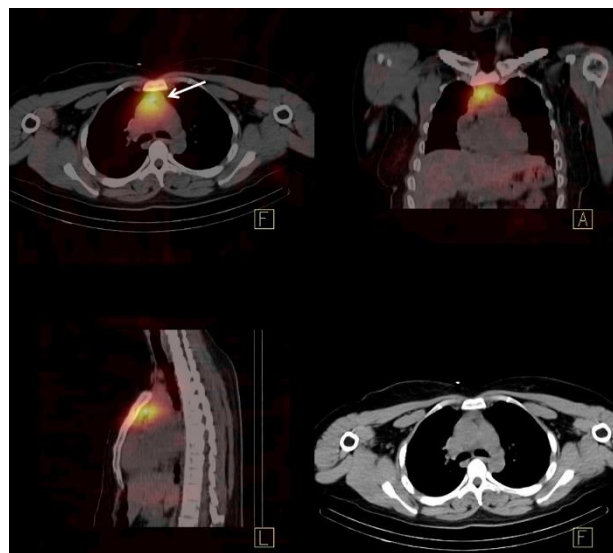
SPECT/CT of the chest showed radioiodine uptake in the anterior mediastinum compatible with thymus (arrow).
